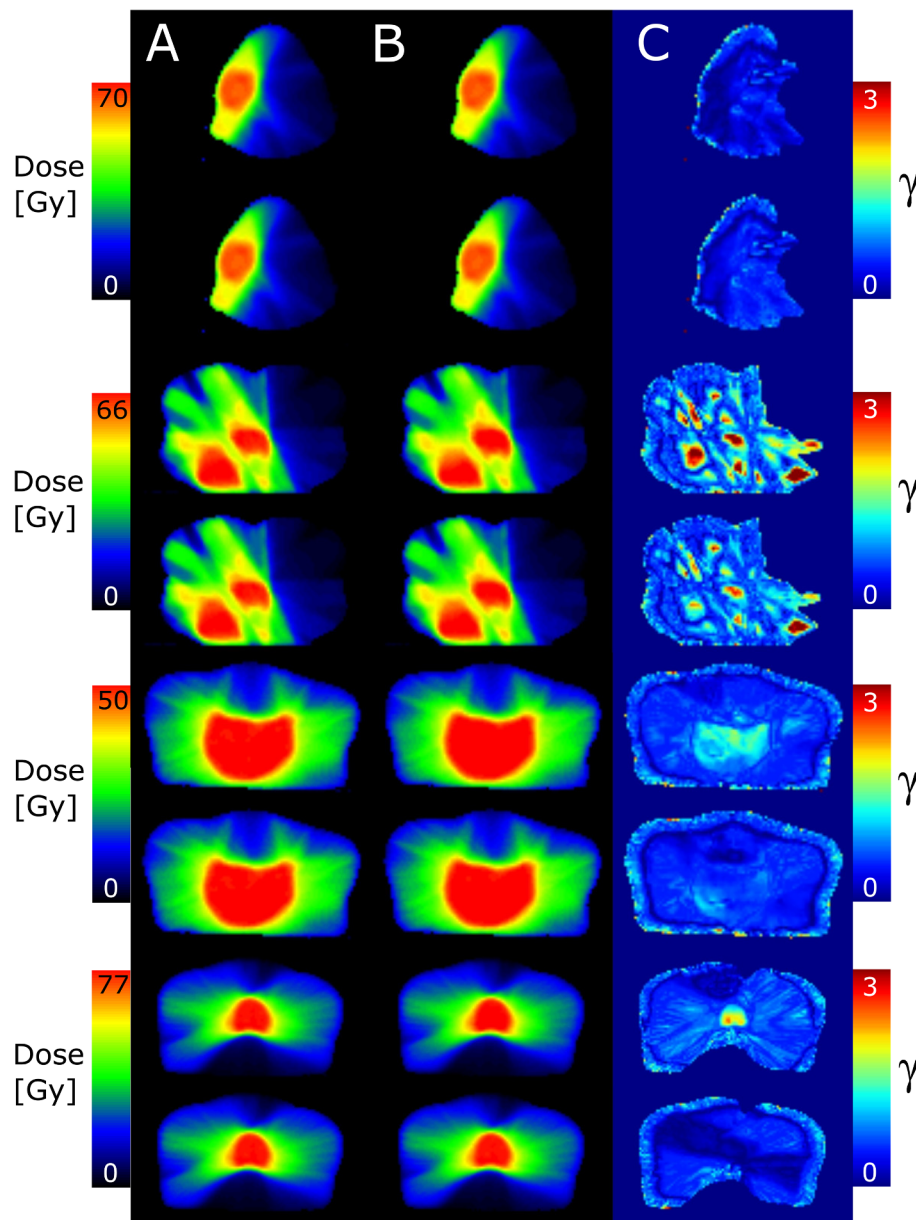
Dose distributions based on the mCT (column A) and CBCT (column B) and the corresponding γ -map (column C) for one patient of each disease site (C1). For each patient USC (upper row) and ISC (lower row) are presented. From top to bottom the disease sites are head and neck, lung, pelvic region, and prostate. The colorbars for A and B are scaled to the planned dose. Discontinuities on the right side of H&N and lung are because the minimum dose for A and B is set to 10% of the maximum mCT dose to avoid problems for the gamma calculation at low doses. This does not influence the γ analysis because the evaluation is up to the 20% isodose.
